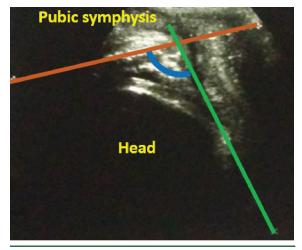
Transperineal ultrasound image of angle of progression.
